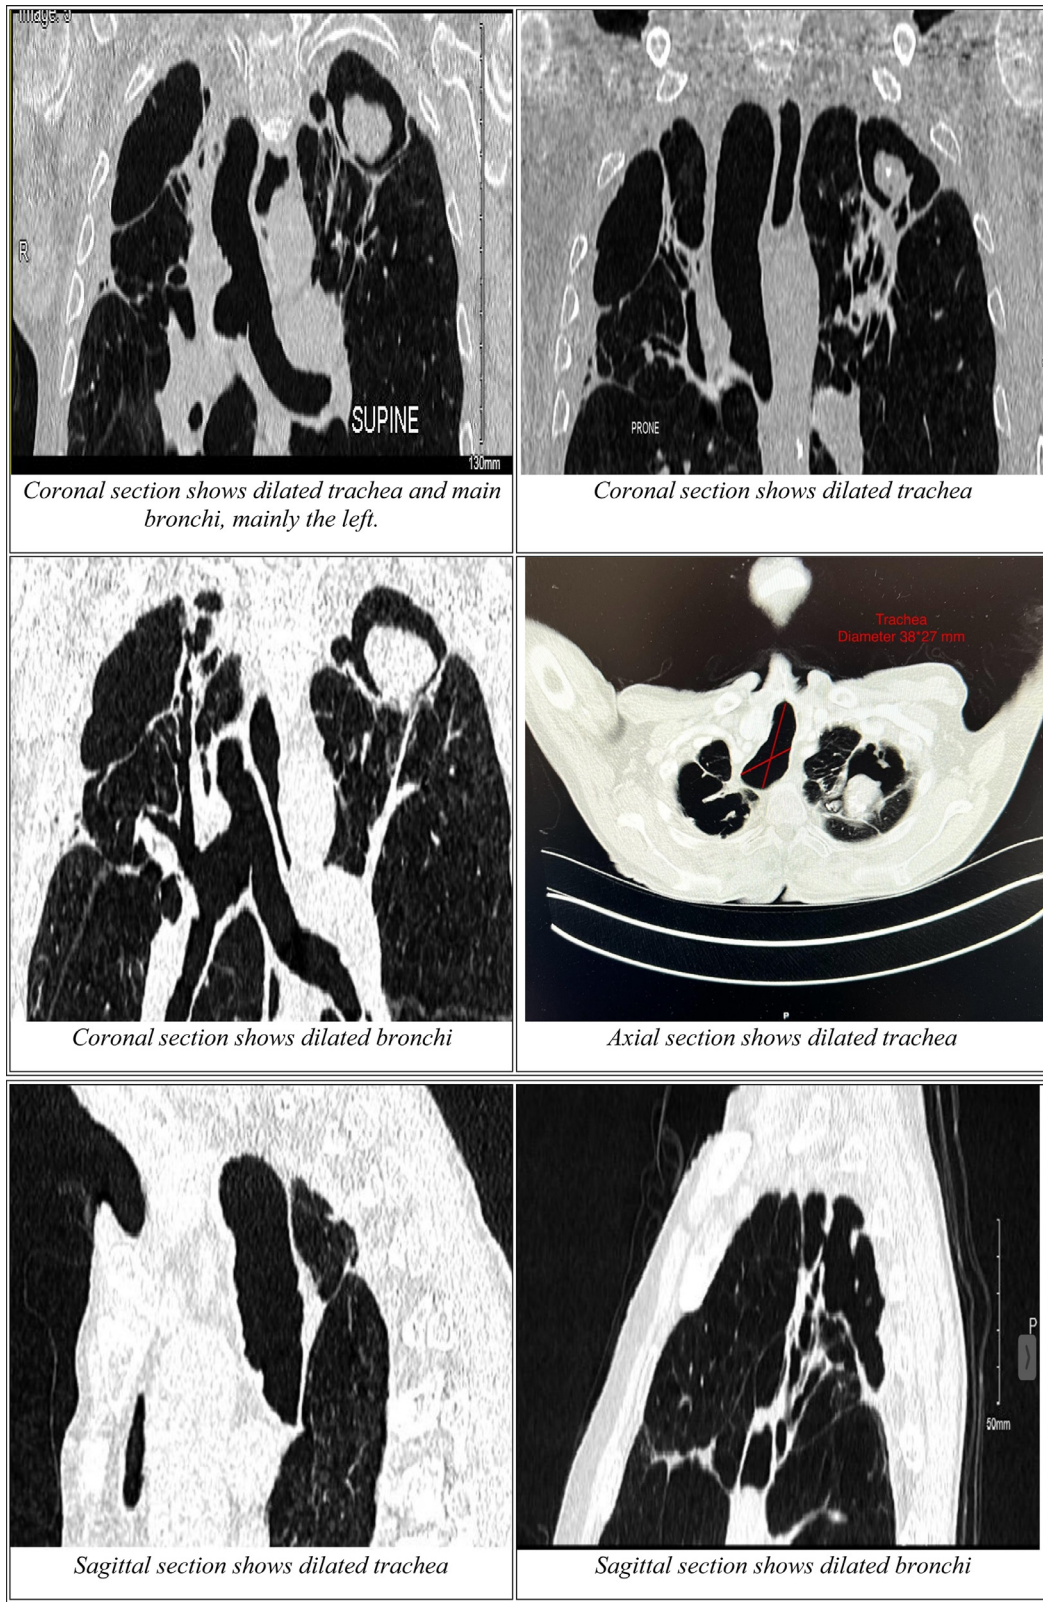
Chest CT reveals dilated trachea and main bronchi, and aspergilloma on coronal, axial and sagittal sections.
